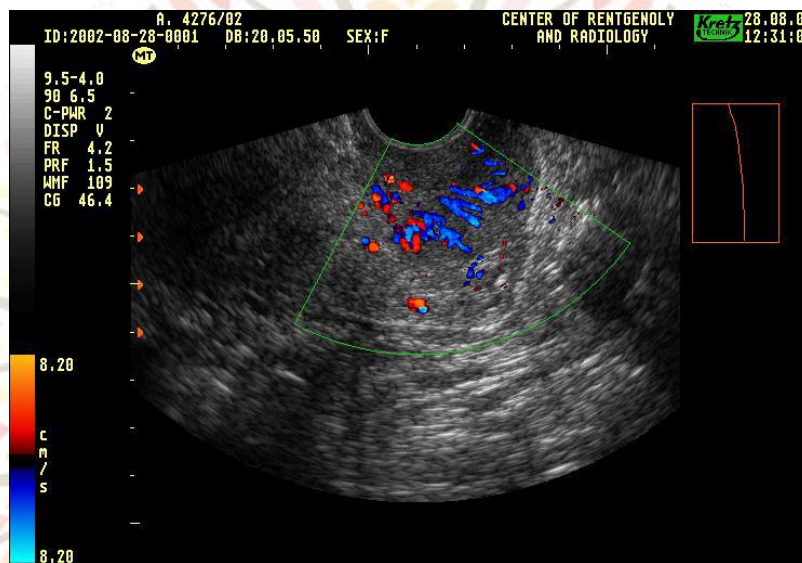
Doppler SEM of stage IB2 in CFM mode.
